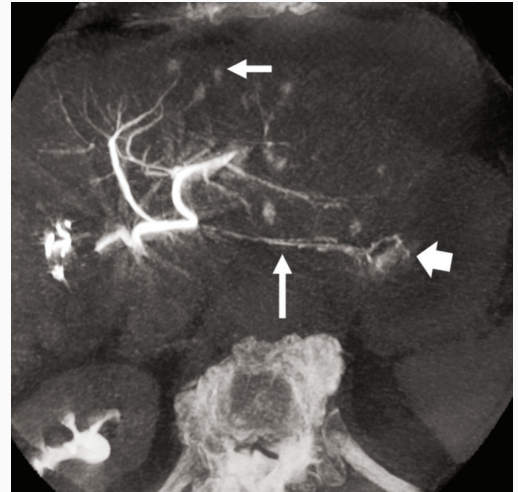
Cone-beam CT of the left hepatic arterial injection shows the accessory left gastric artery (vertical arrow) with associated gastric mucosal enhancement (block arrow). Also noted are multiple hypervascular hepatic tumors (horizontal arrow).
